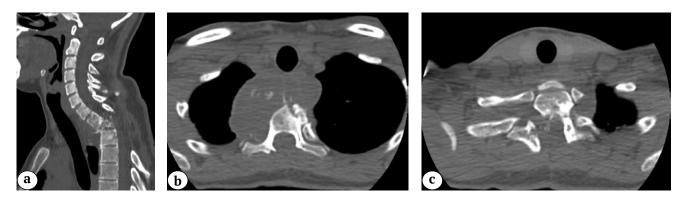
CT images at the time of hospital admission: a — sagittal view: Th1-2 destruction, angular cervico-thoracic kyphosis 56° Cobb; b, c — axial view: paravertebral cyst, mainly located in the right paravertebral side, postlaminectomy defect C7-Th4
